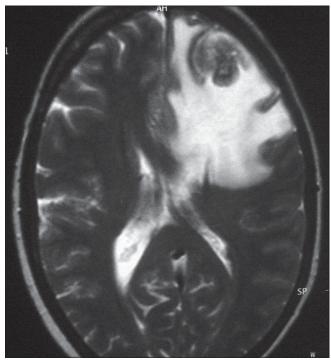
MRI brain T2WI (axial view) showing isointense to hypo intense lesion in the left frontal lobe
